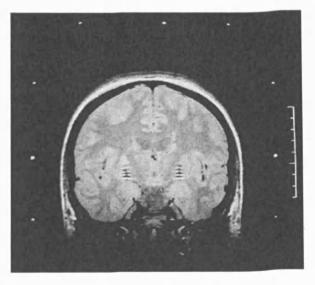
Immediate post-implantation axial and coronal MRI images of patient 1 showing quadripolar 3387 electrodes located bilaterally in the GPi.
